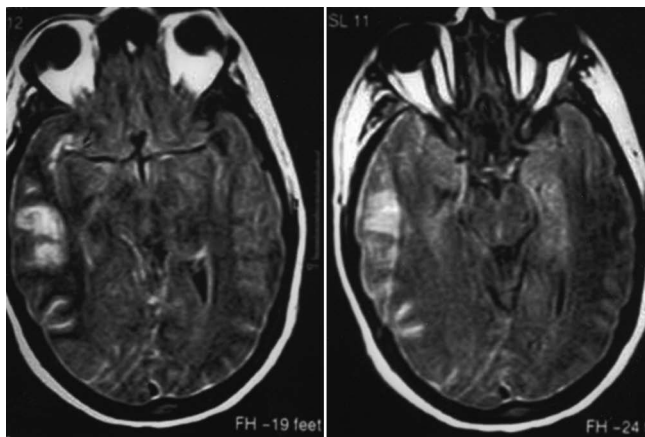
Magnetic resonance images revealing an area of venous hemorrhagic infarction on the right temporo-parietal lobe.
